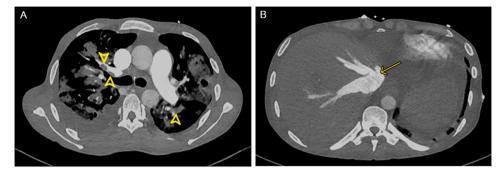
A CT pulmonary angiogram at a level below the tracheal carina showing (A) markedly dilated main and branch pulmonary arteries. Multiple filling defects are seen within the distal pulmonary arteries bilaterally (arrow heads). (B) Contrast reflux into the dilated hepatic veins (arrows) consistent with severe tricuspid regurgitation.
